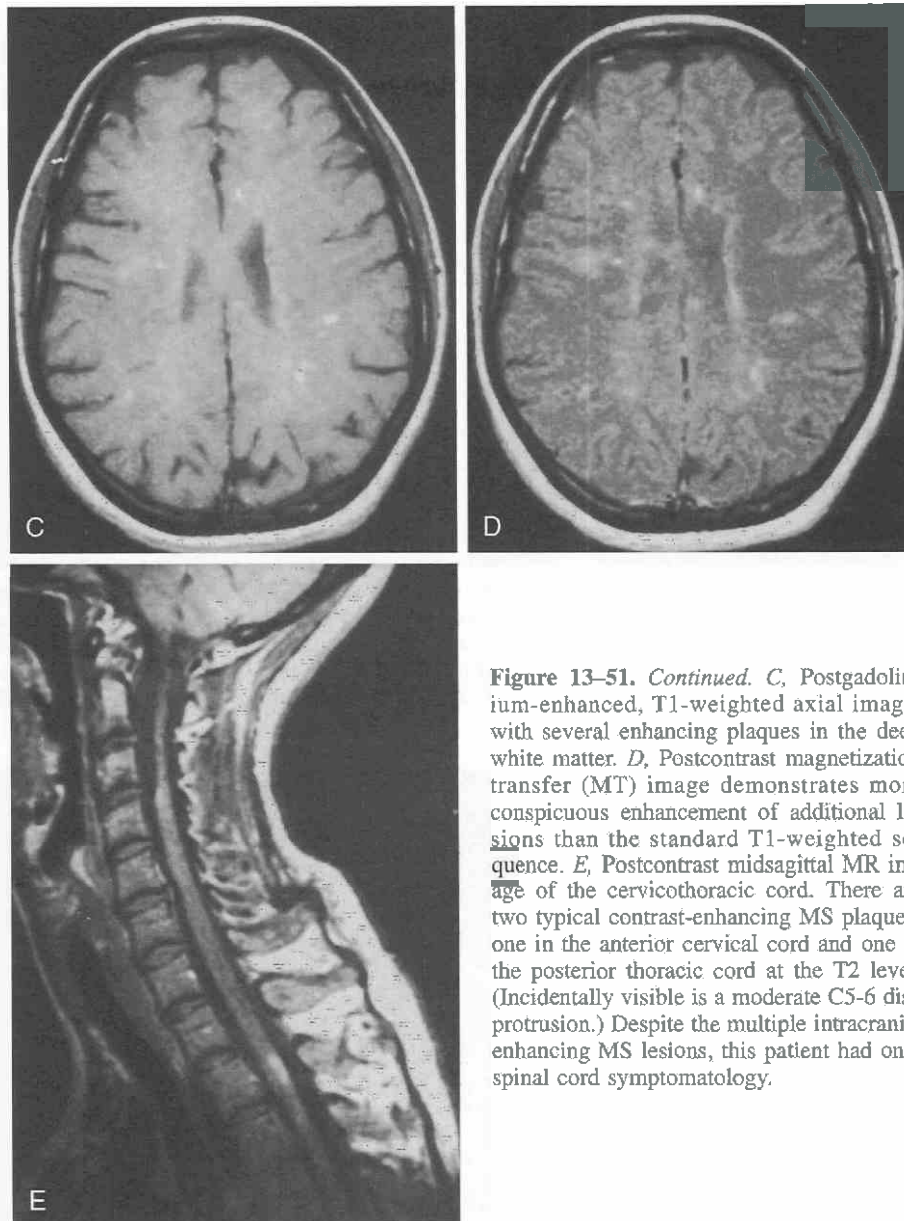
Continued.* C, Postgadolinium-enhanced, T1-weighted axial image, with several enhancing plaques in the deep white matter. D, Postcontrast magnetization transfer (MT) image demonstrates more conspicuous enhancement of additional lesions than the standard T1-weighted sequence. E, Postcontrast midsagittal MR image of the cervicothoracic cord. There are two typical contrast-enhancing MS plaques: one in the anterior cervical cord and one in the posterior thoracic cord at the T2 level. (Incidentally visible is a moderate C5-6 disk protrusion.) Despite the multiple intracranial enhancing MS lesions, this patient had only spinal cord symptomatology.
